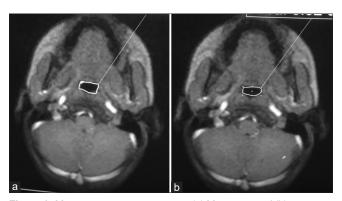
Magnetic resonance imaging (a) Maximum and (b) minimum cross-sectional areas at the level of the soft palate
